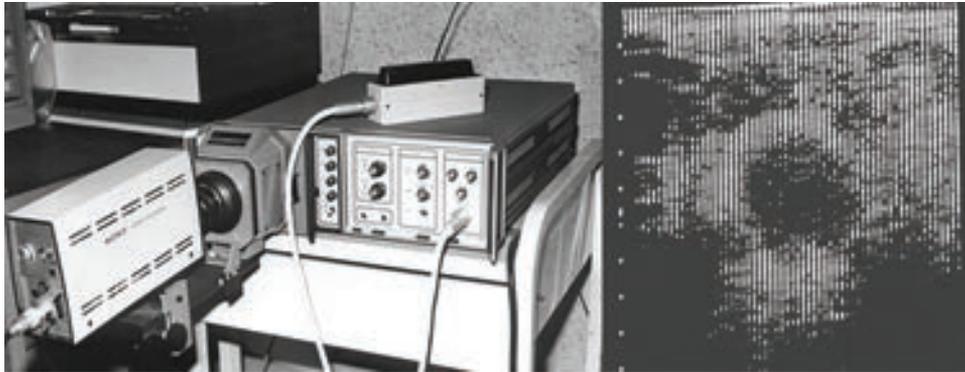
Early linear electronic scan real-time B-mode, ADR2130, 1975, composed of 64 ultrasound units. It achieved low-grade sonogram, because neither interlace nor focusing was prepared. Sonogram was improved in later machines
